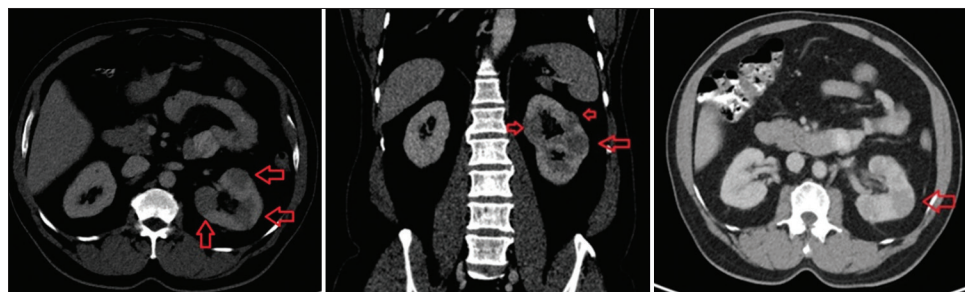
Triphasic CT scans revealing granulomatosis of the left kidney and the regression changes after anti-tuberculosis therapy and granulomatous change of the left kidney. CT: Computed tomography. The red arrows indicate areas of hypodensity in the renal parenchyma
